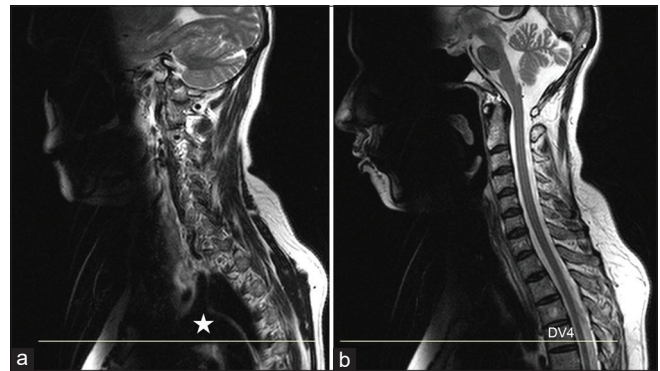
T2-weighted sagittal images. (a) Reference line across the summit of inferior concavity of aortic arch (star). (b) Reference line extending up to the fourth dorsal vertebra
